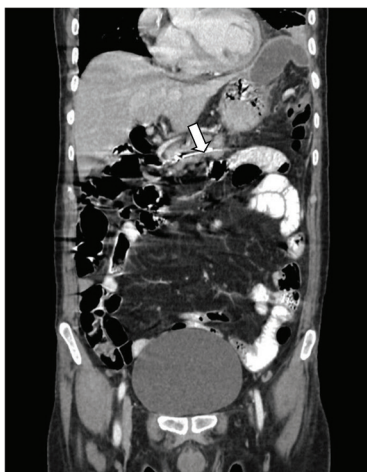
Coronal CT section shows MPD stent in situ (Arrow).
